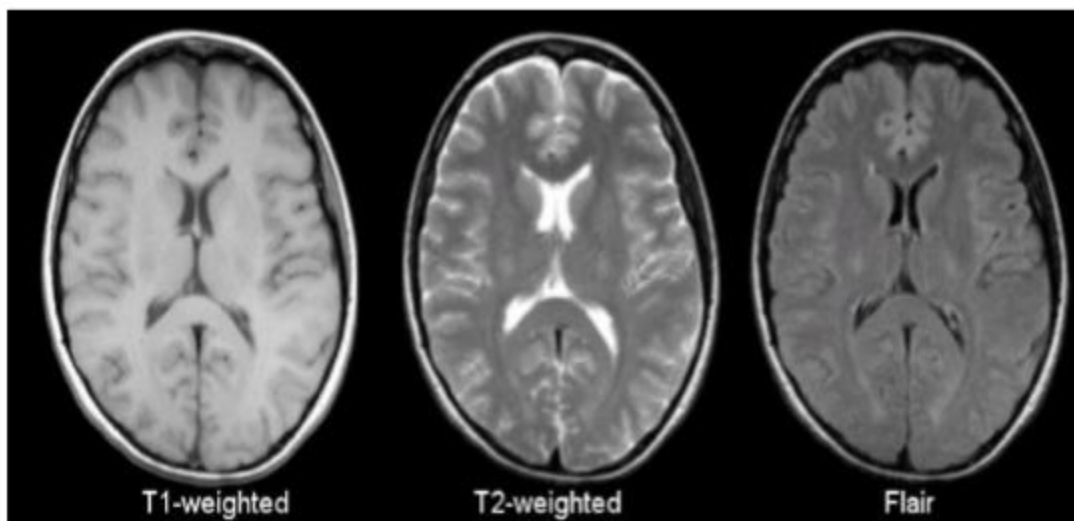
In this fig.different images technique of MRI are shown[77].
